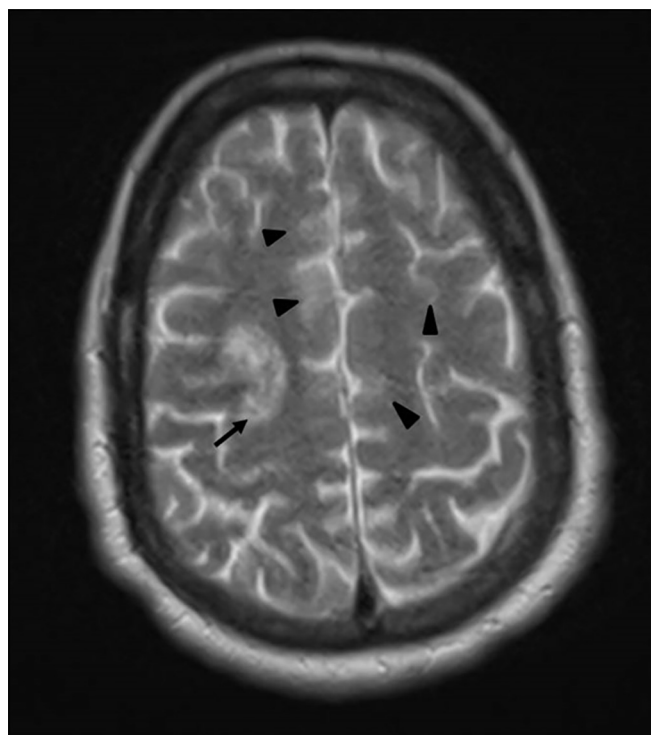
Multifocal lesions distributed in both cerebral hemispheres (arrow heads) and a right frontal hemorrhagic component (arrow) observed on T2 brain magnetic resonance imaging.
